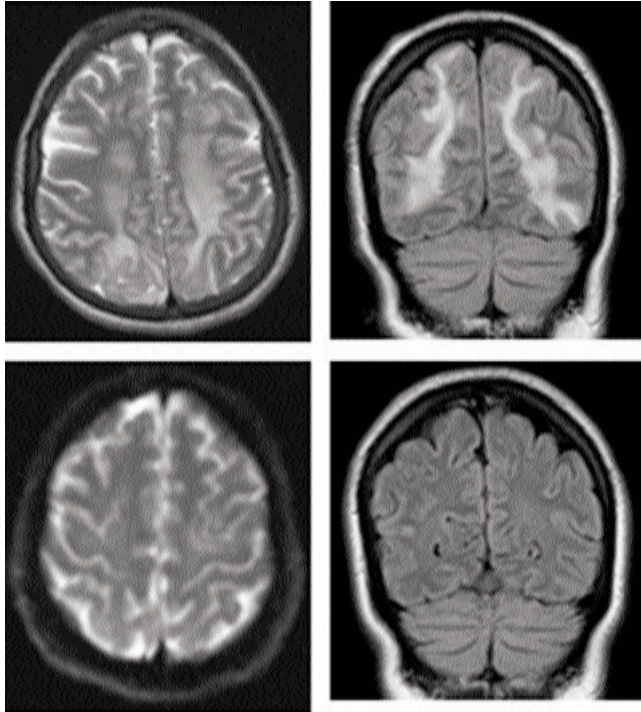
(a)- T2-weighted axial image shows diffuse hyperintense signal in deep white matter and subcortical white matter in bilateral frontal and occipital regions. (b)- Coronal FLAIR image shows diffuse hyperintense signal in deep white matter and subcortical white matter along the frontal and occipital regions. (c)- Diffusion-weighted image shows no evidence of diffusion restriction. (d)- Follow-up coronal FLAIR image shows complete resolution of previously noted abnormal signals.
